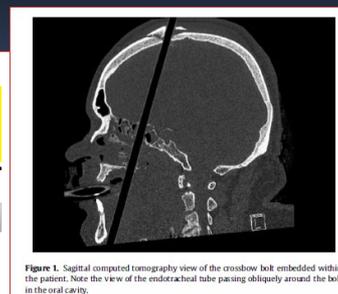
Sagittal computed tomography view of the crossbow bolt embedded within the patient. Note the view of the endotracheal tube passing obliquely around the bolt in the oral cavity.
